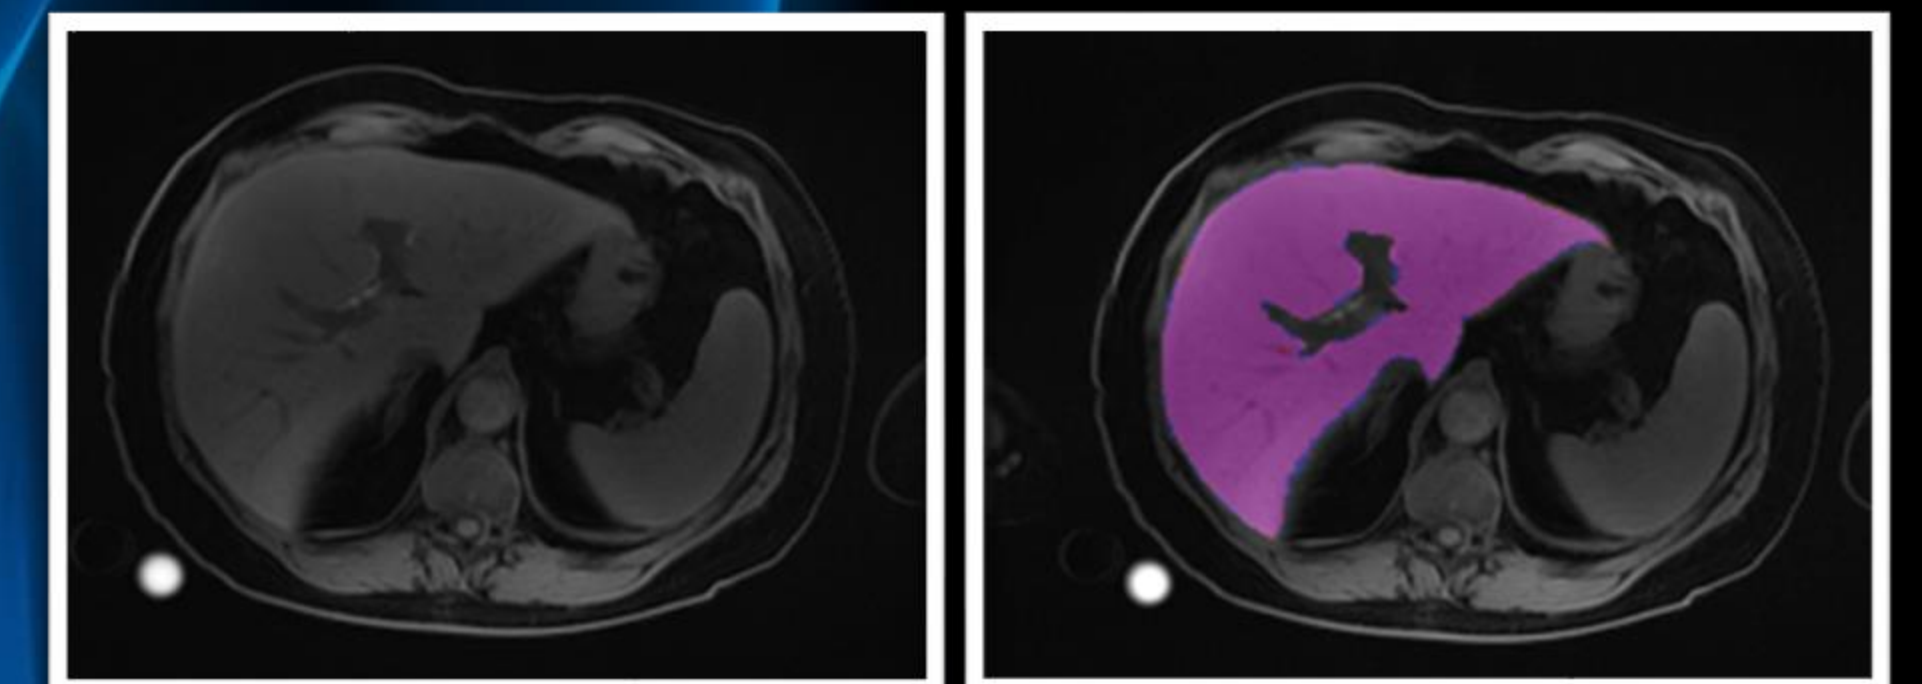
the two figures above show the unsegmented MRI scan on the left and the proposed liver volume segmentation from our model. Where purple is correct, red is under-segmentation and blue is over-segmentation. Here the proposed segmentation overlaps almost perfectly.
